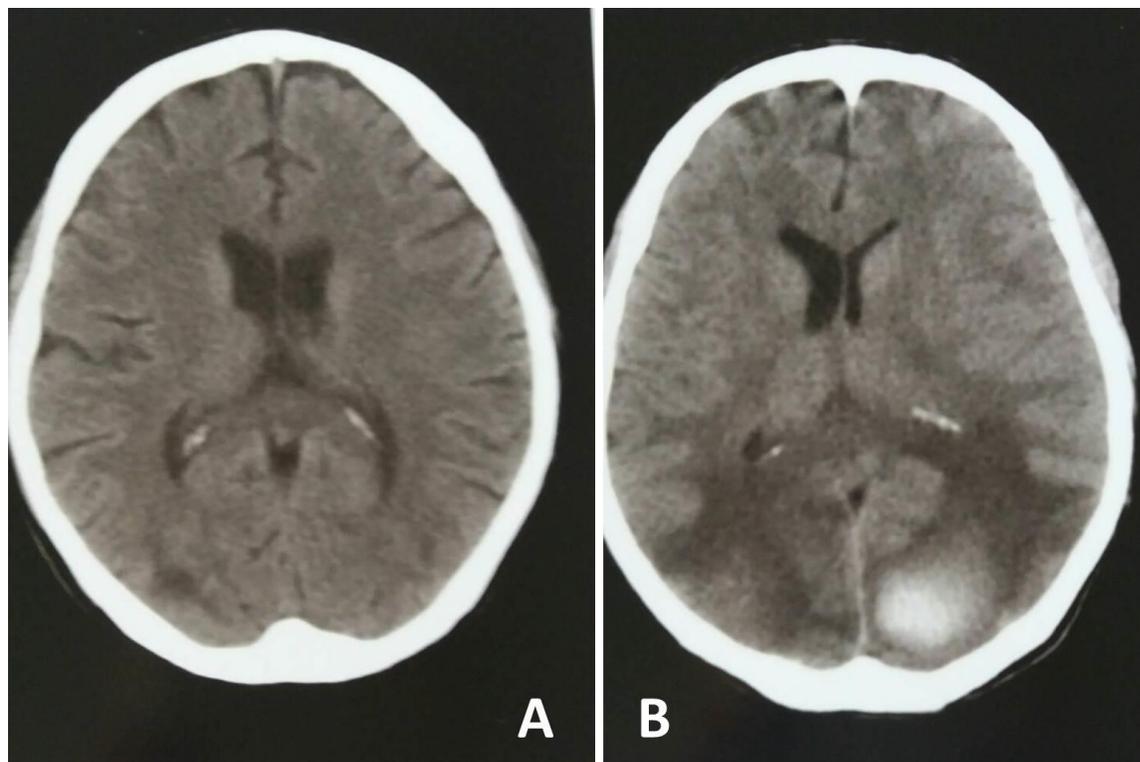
CT of the brain of the patient
